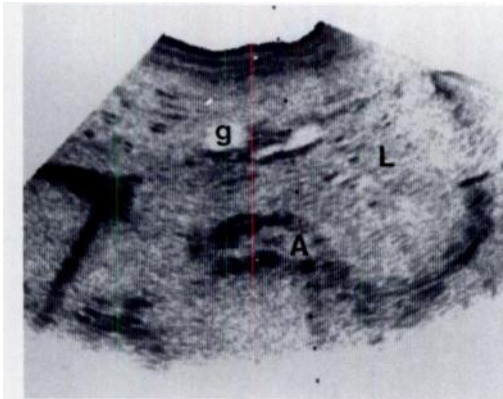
Total situs inversus, case 19, 6-year-old boy, transverse sonogram. Left-sided liver (L) and left-sided inferior vena cava (IVC, arrow). Aorta (A) to right of spine.
